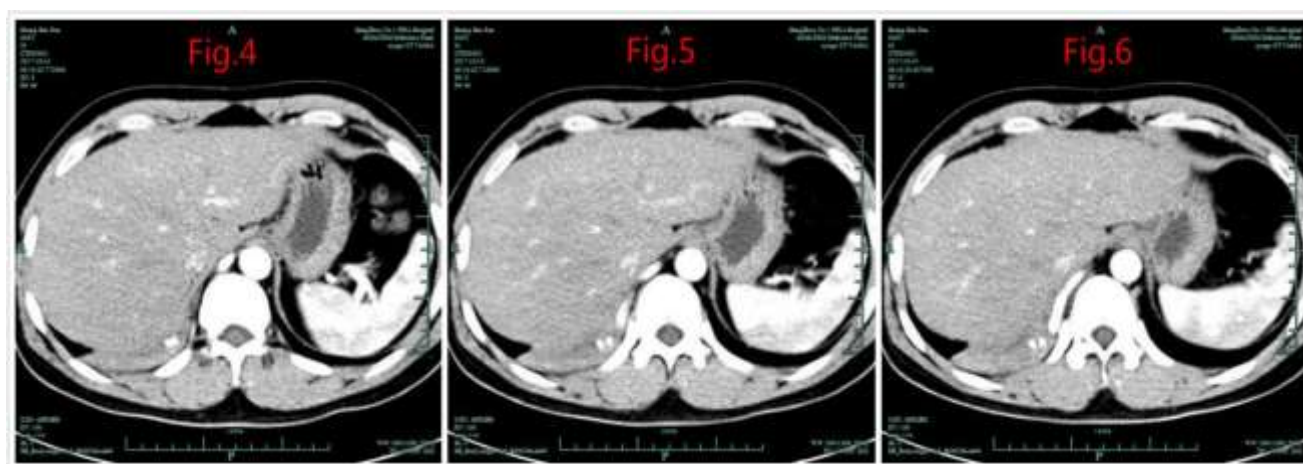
the branches of the blood supply to the lower lobe of the right lung can be seen in CTA
